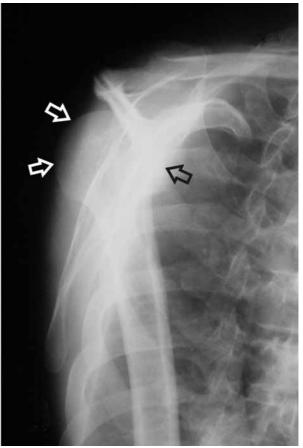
True anteroposterior (A) and lateral (B) radiographs of the right shoulder. A. Note the humeral head lesion (black arrows) and osteochondral fragments in the joint (white arrows). B. Note the posterior position of the dislocated humeral head (white arrows) in relation to the glenoid (black arrow).
